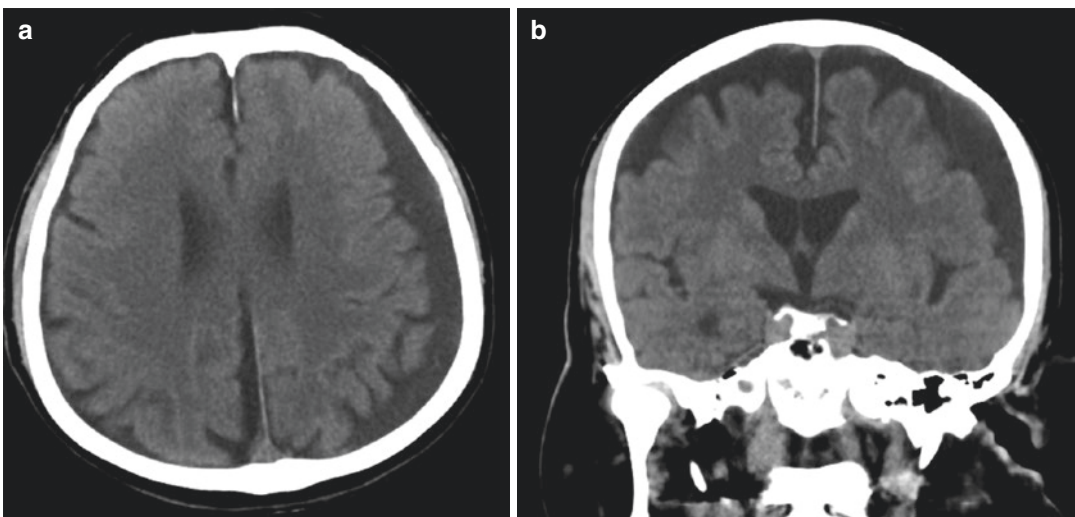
Axial (a) and coronal (b) computed tomography (CT) images of a case of chronic subdural hematoma (cSDH) of an asymptomatic patient
